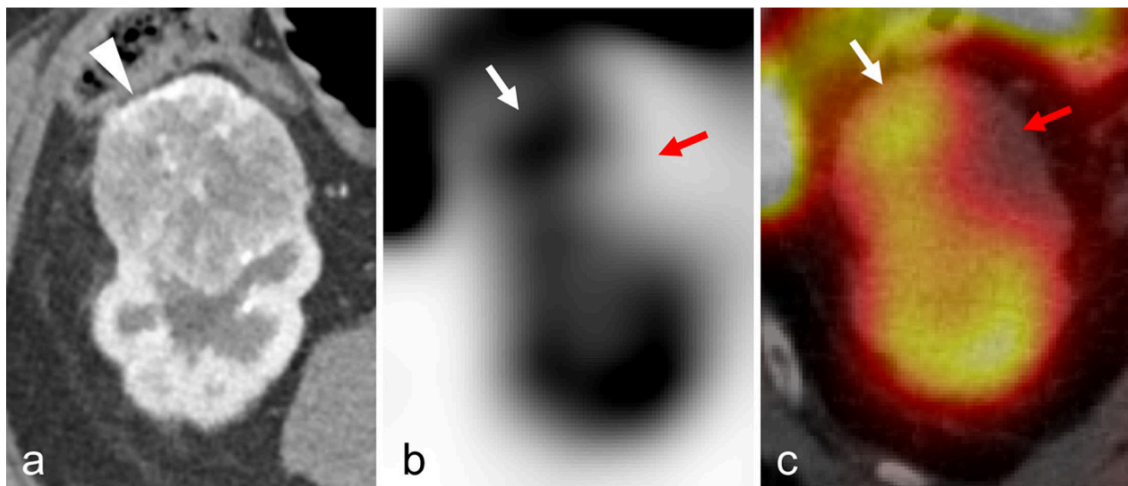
(a) Axial arterial/corticomedullary phase contrast-enhanced CT, (b) axial ^{99m}Tc -sestamibi SPECT, and (c) axial ^{99m}Tc -sestamibi SPECT/CT fusion images demonstrating a tumour [white arrowhead in (a)] with heterogeneous uptake. Portions of the tumour have radiotracer uptake similar to renal parenchyma [white arrows in (b, c)] and other portions are distinctly low in uptake [red arrows in (b, c)]. This is another uptake pattern that suggests a benign or indolent lesion, and this tumour was found to be a HOCT upon resection.
